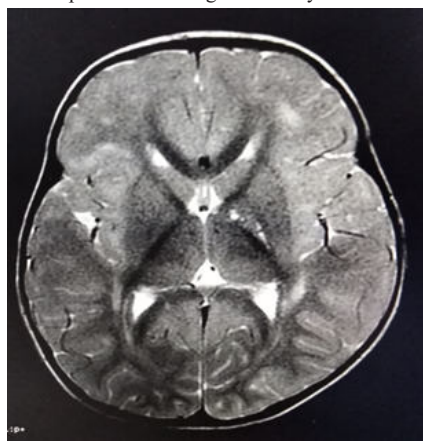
Magnetic Resonance Imaging. Bilateral hyper intensities in periventricular and subcortical white matter in T2 weighted image.
